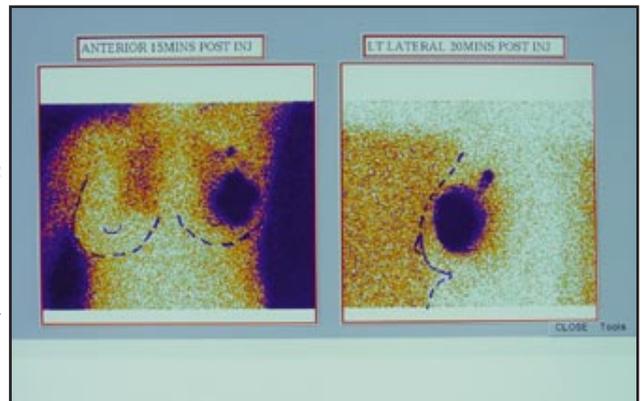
Lymphoscintigram showing injection site (large hotspot) and Sentinel Node (small hotspot)
